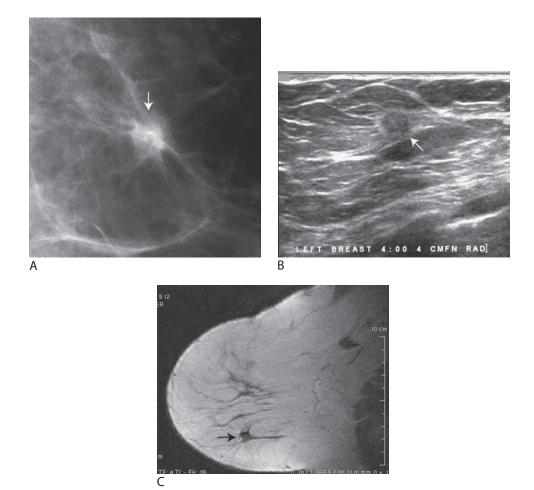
Invasive ductal carcinoma NOS, well differentiated (grade I). (A) Spot compression view demonstrating a mass with indistinct and spiculated margins (*arrow*). When spiculated, these tumors are commonly well or intermediately differentiated. (B) A nearly isoechoic mass (*arrow*) with an echogenic rim is imaged at the 4 o'clock position, 4 cm from the left nipple corresponding to the mass seen mammographically. (C) Sagittal T1 weighted MRI demonstrating a mass with spiculated margins (*arrow*) and low signal intensity corresponding to the mass seen mammographically. Rapid initial enhancement with wash out of contrast (not shown) is noted following contrast administration.
